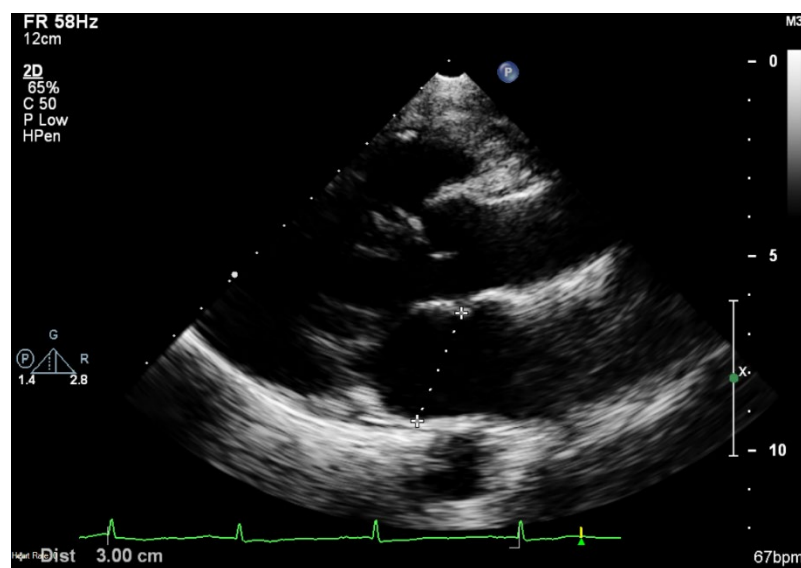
Left atrial diameter measured by transthoracic echocardiography
